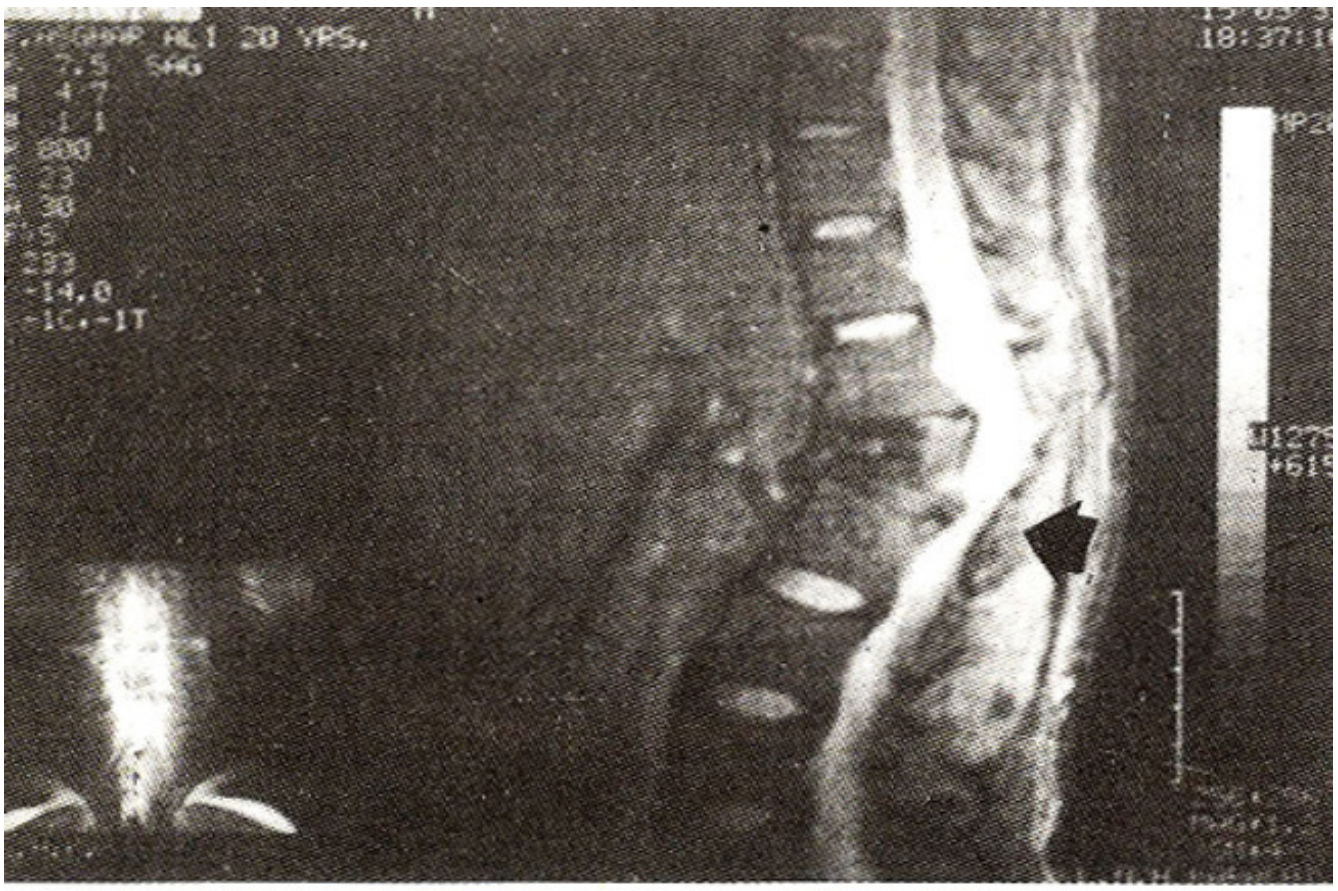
Sagittal MRI image showing spinal cord compression and angulation.
